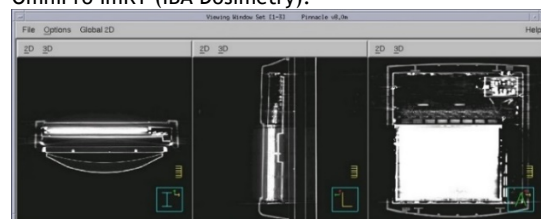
Acquired CT images of the Varian aS1000 EPID. Results
